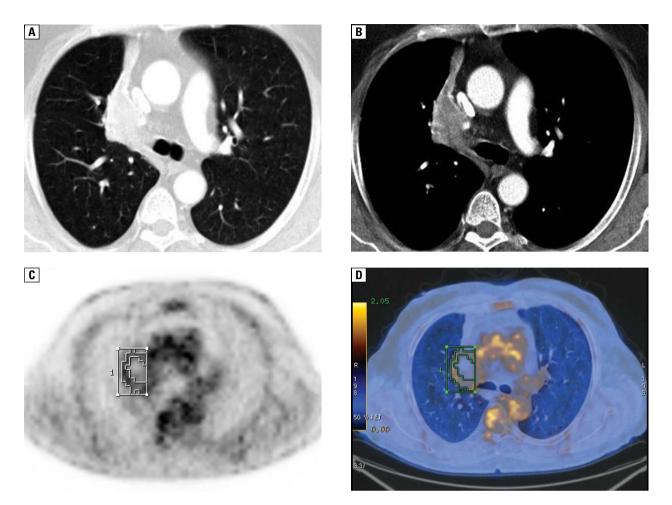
Carcinoid of the right upper bronchus. A, B — lung and mediastinal window of enhanced CT scan show a mass in the right upper lobe; C, D — mass shows little 18F-FDG uptake on PET-CT image
